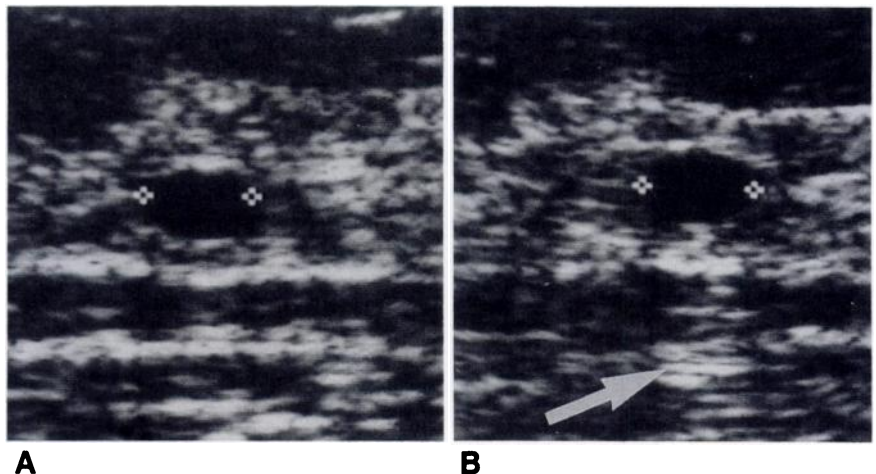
Sonograms of 0.5-cm cyst showing variable distal echo enhancement. A, Cyst (between cursors) interior is clearly anechoic, but distal echo enhancement is not seen. B, Same cyst, imaged with slightly less transducer compression and a slight change in direction of ultrasound beam. Distal echo enhancement (arrow) is demonstrated.
